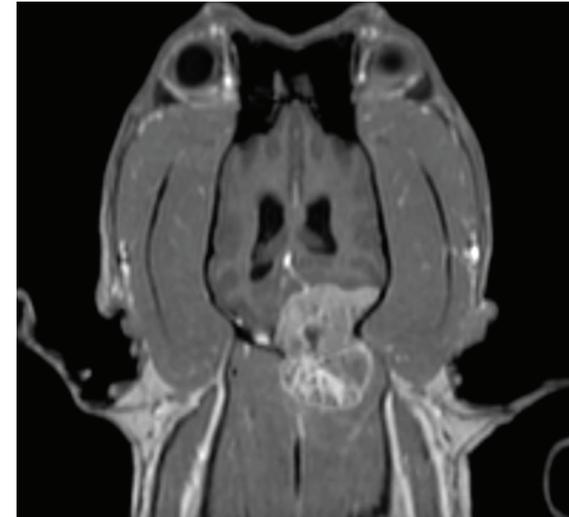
MRI of case 1 shows a large mass originating from occipital bone with inward expansion to the the cerebellum.
